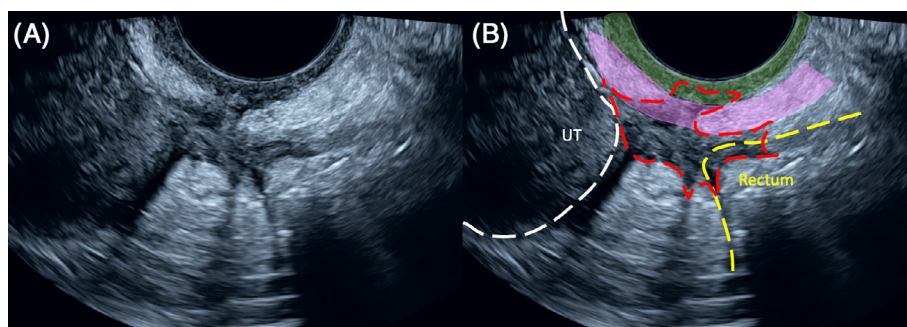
A transvaginal ultrasound image of a nodule of deep endometriosis originating within the right uterosacral ligament (A). Deep endometriosis will often infiltrate into surrounding anatomical structures. In this case, this lesion can be seen infiltrating into the vaginal wall, rectum and adhering to the uterus. Image (B) is the same image marked up to highlight the relevant anatomy. The nodule is demarcated with the red dashed line. Green = posterior vaginal wall, pink = uterosacral ligament, yellow dashed line = anterior rectal wall and white dashed line = uterine serosa.
